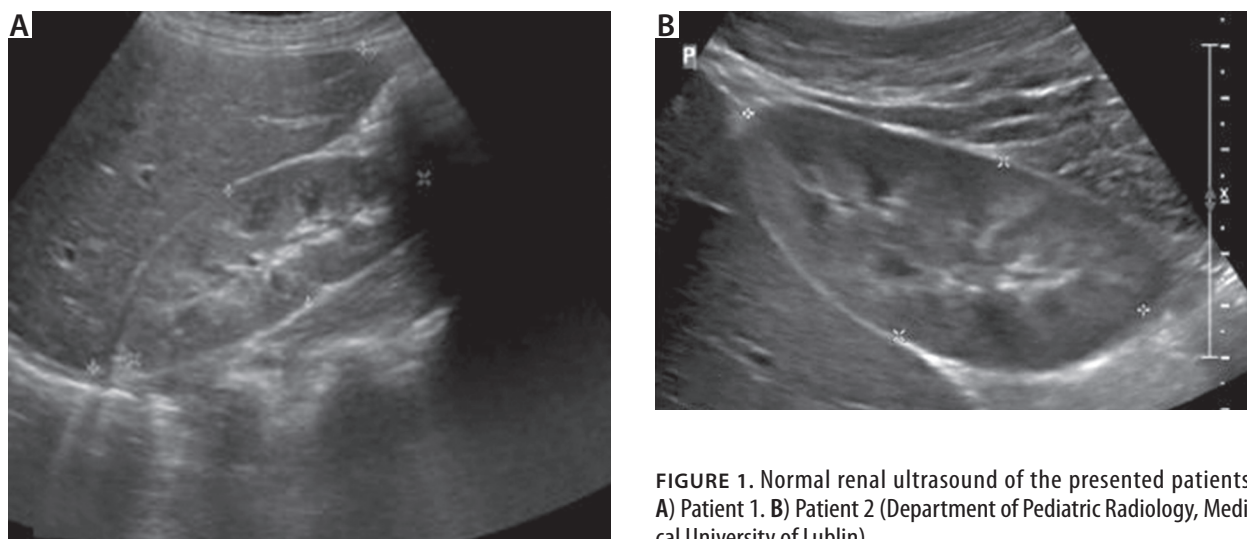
Normal renal ultrasound of the presented patients. A) Patient 1. B) Patient 2 (Department of Pediatric Radiology, Medical University of Lublin)
